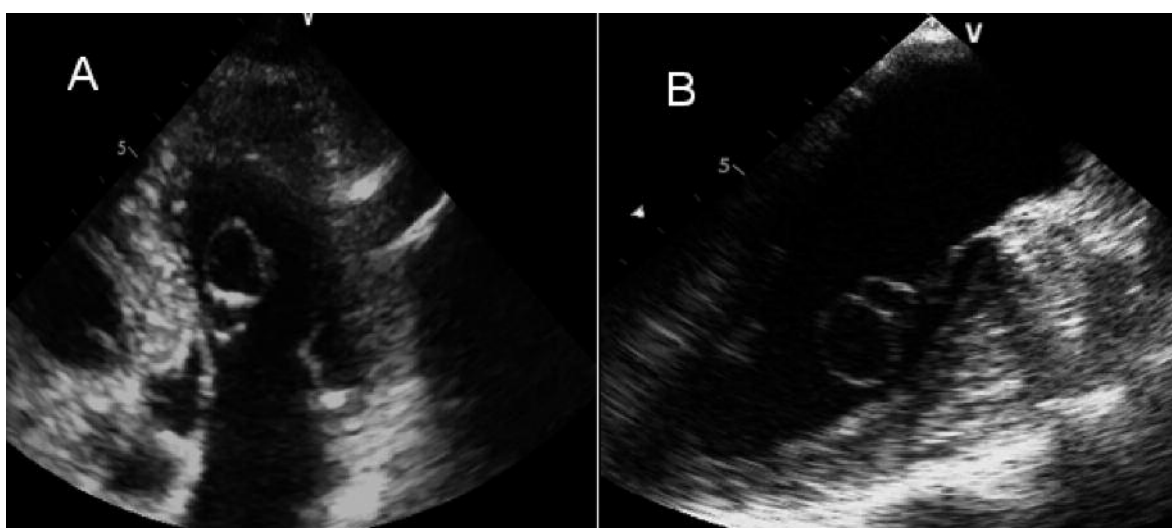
A, Echocardiographic view of AMVT obtained from apical four chamber. B, TEE showed attaching to anterior mitral leaflet of AMVT tissue.
